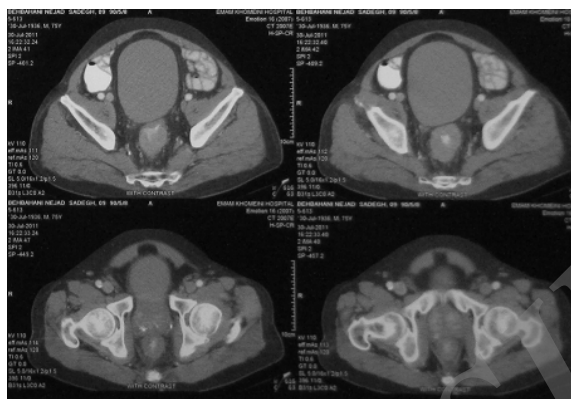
Bulky rectal tumor in Spiral Pelvic CT-Scan
